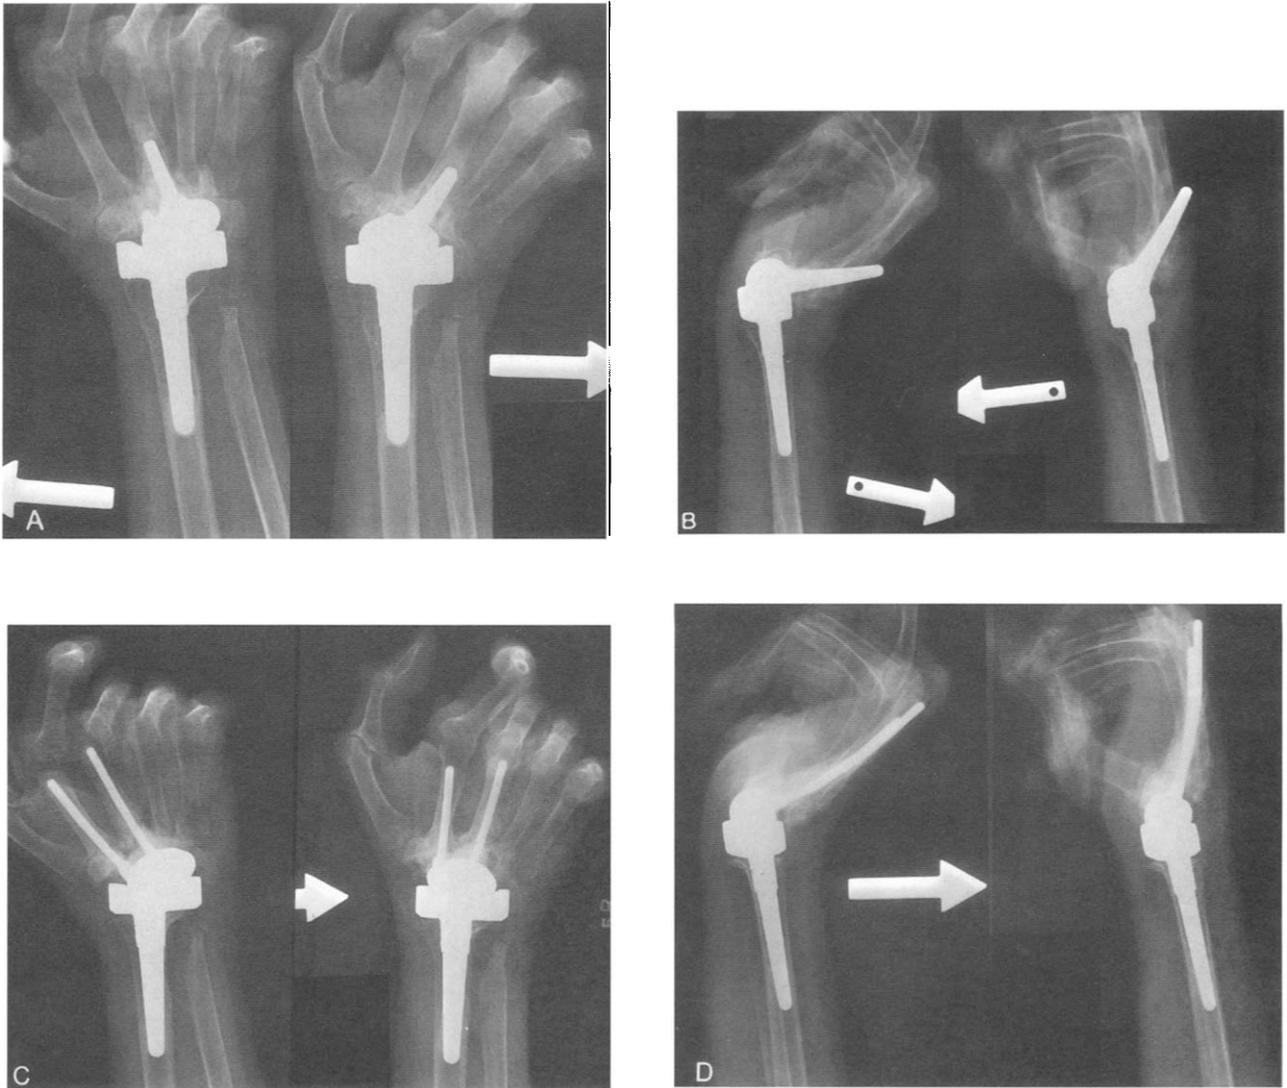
A 66-year-old woman with severe rheumatoid arthritis. Figures A and B, are radiographs at 6 years after primary total-wrist arthroplasty. (A) Anteroposterior view with radial and ulnar deviation. (B) Lateral view with flexion and extension; note loosening of distal implant with dorsal migration and gross motion with wrist range of motion. Figures C and D are radiographs at 15 months after revision arthroplasty with custom two-pronged distal component. (C) Anteroposterior view with radial and ulnar deviation. (D) Lateral view with flexion and extension.
